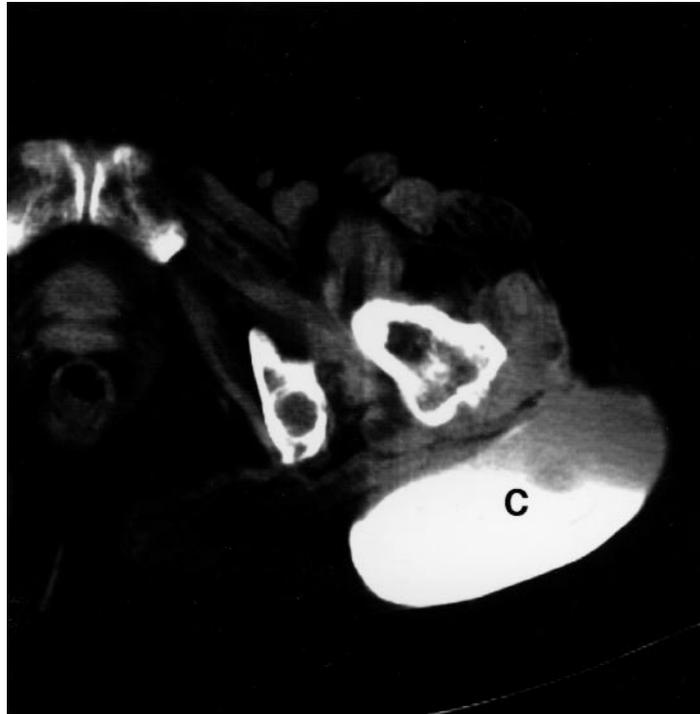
Computed tomography scanning of the pelvis. Contrast medium was injected into the subcutaneous cyst (C). A communication with the trochanteric bursa or the hip joint was not present.
